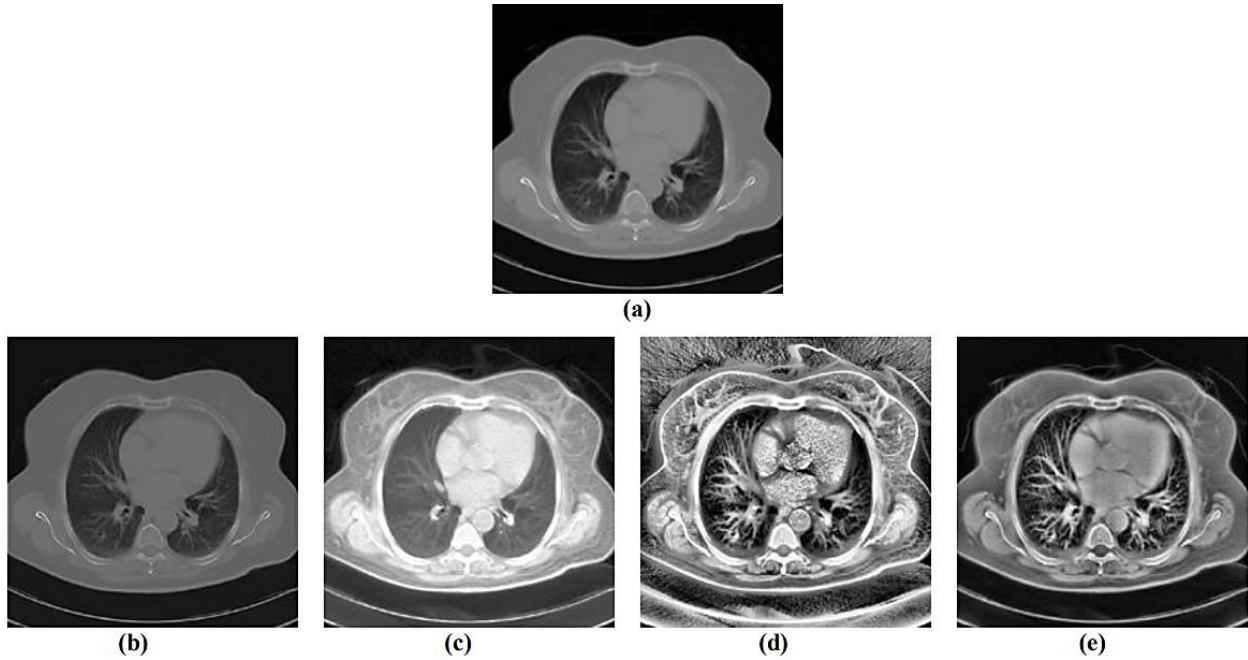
Contrast enhancement of a chest CT image using traditional techniques: (a) original image; (b) unsharp masking; (c) histogram equalization (HE); (d) adaptive histogram equalization (AHE); and (e) contrast-limited adaptive histogram equalization (CLAHE). Adapted (Jin et al., 2001a)
